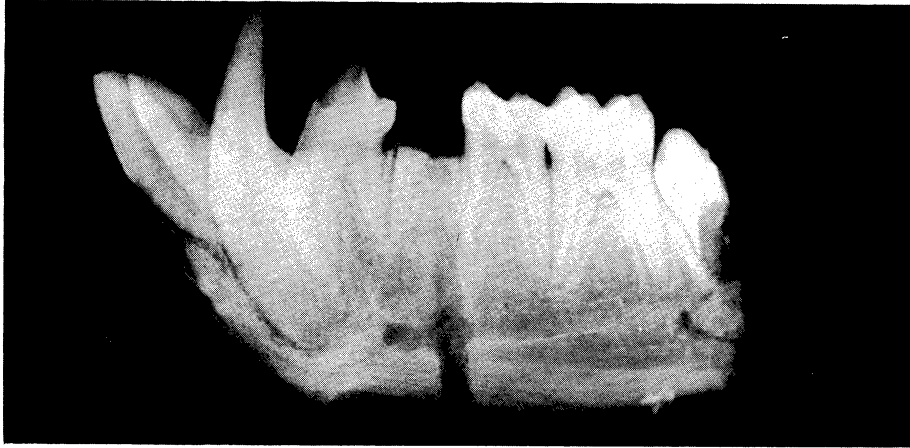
Lateral jaw X-ray three weeks following fracture into which cyanoacrylate monomer was incorporated.
